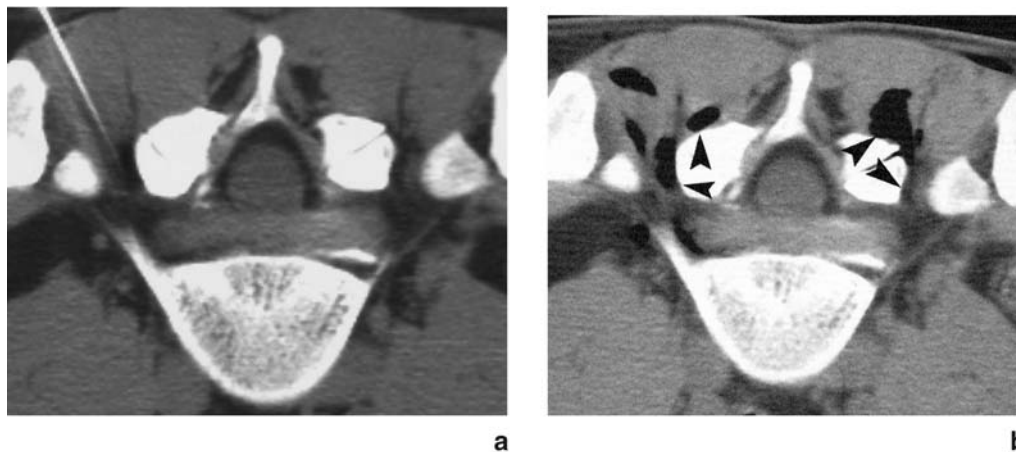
(a,b). (a) CT image of the needle (arrowhead) inserted into the periganglionic region, (b) distribution of the gas mixture in the periganglionic region and facet joints (arrowheads)
